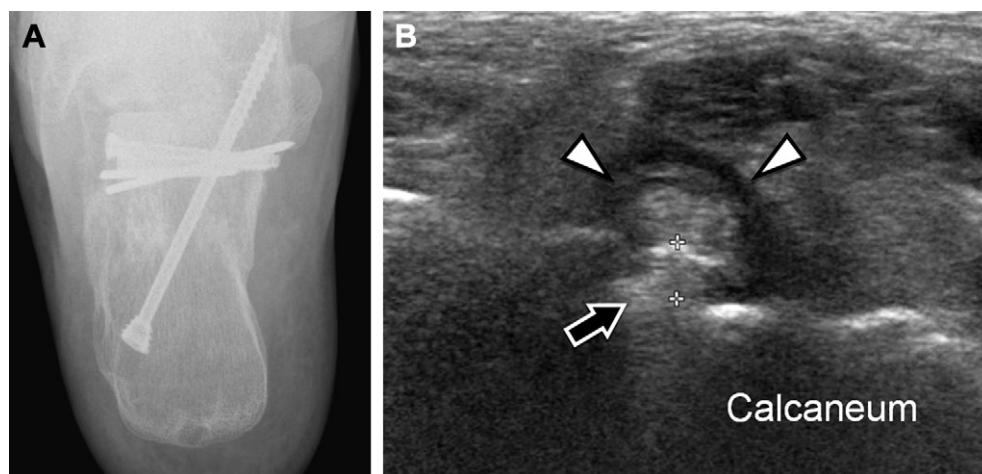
A. Protrusion of a screw tip from the anterior aspect of the calcaneus. B. Ultrasound confirms the existence of screw impingement on the flexor hallucis longus tendon, which presents obvious structural damage.
